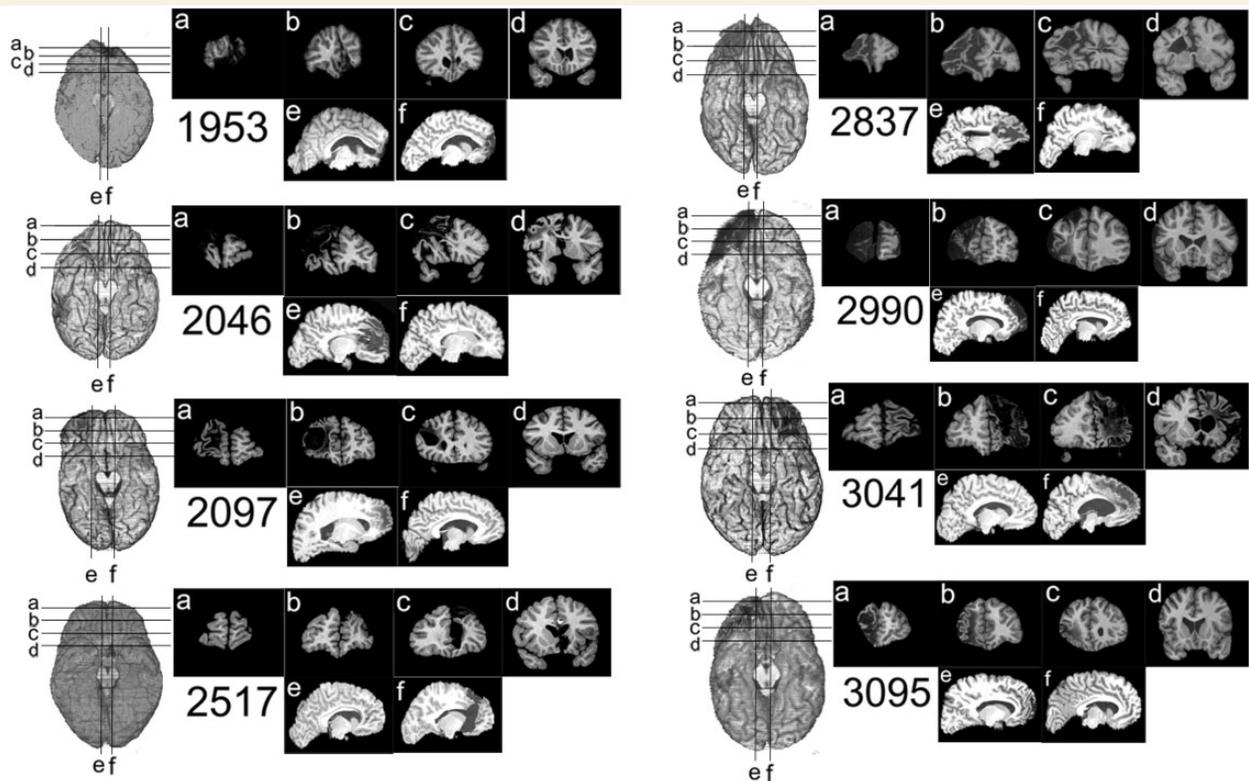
Developmental-onset ventromedial PFC patient brain images from MRI scans. A ventral view of each patient's brain is presented below their Subject ID. To the right of the ventral view, four coronal (a–d) and two perisagittal (e–f) cross-sections are shown, in radiological convention (left hemisphere on the right and vice versa). The lesions are evident as hypodense (black) areas in these images.
